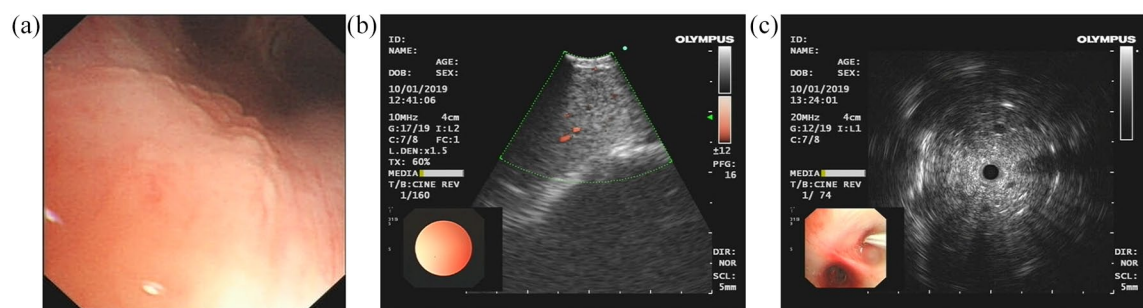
Bronchoscopy showed local uneven membrane surface (A), hypoechoic areas in group 7, 4R, and 11Rs mediastinal lymph nodes through CP-EBUS (B), and hypoechoic shadow in the dorsal segment of the right lower lobe through RP-EBUS (C). CP-EBUS, convex-probe endobronchial ultrasound; RP-EBUS, radial-probe endobronchial ultrasound.
